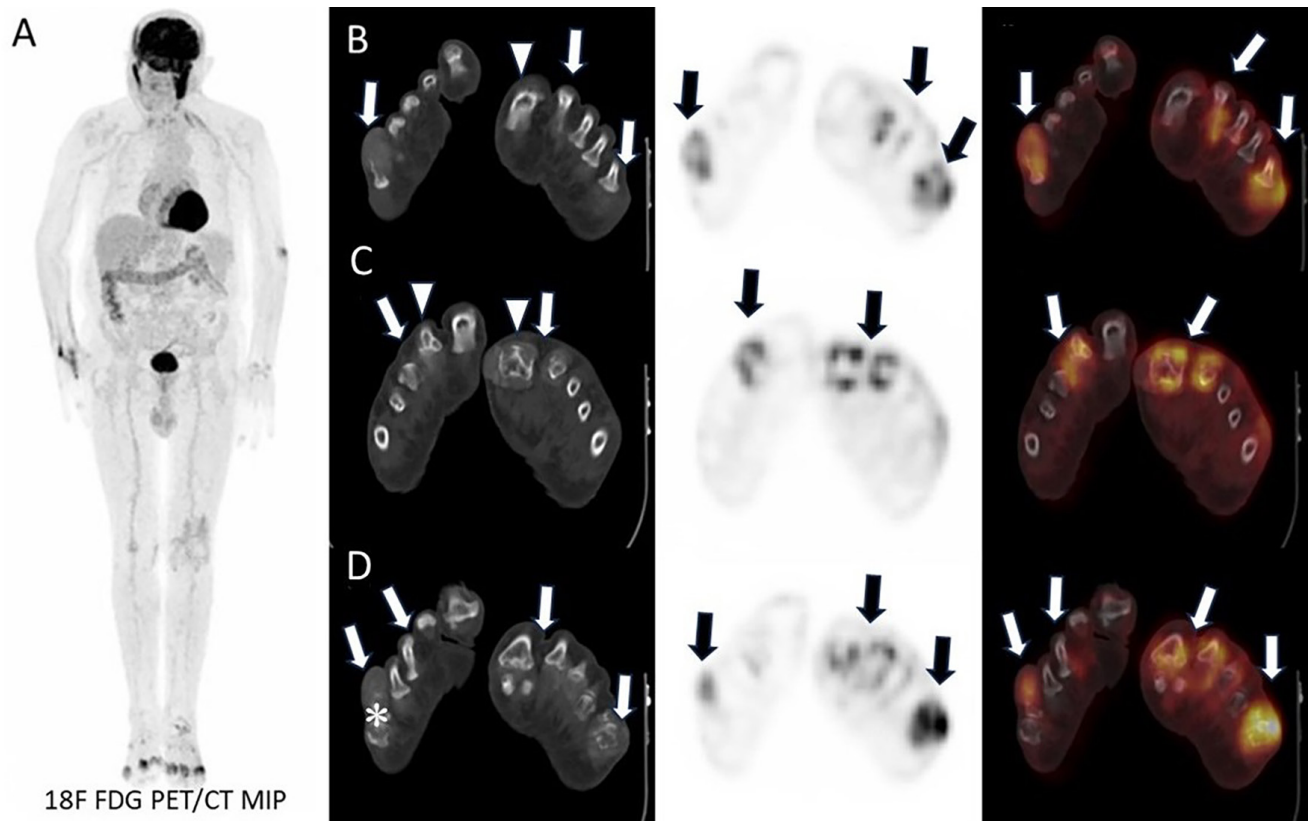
An 84-year-old man, with a known history of hypertension, asthma, and coronary artery disease, presented to the orthopedics clinic with complaints of acute swelling and pain in the right fifth toe. The patient had not experienced similar complaints previously. Magnetic resonance imaging revealed T2 hyperintense nodular images on the articular surfaces of the 1st and 2nd metatarsophalangeal joints of the right foot. A hyperintense mass was observed on imaging distal to the 2nd metatarsal, extending to the phalanx, disrupting the cortex, and spreading into the soft tissue. Additionally, a mass was detected in the distal phalanx of the 5th toe which destroys the bone cortex and extends into the soft tissue. To rule out malignancy, ^{18}F -fluorodeoxyglucose positron emission tomography/computed tomography (^{18}F -FDG PET/CT) was performed (A). Significant increased ^{18}F -FDG uptake was detected in bilateral intertarsal, tarsometatarsal, metatarsophalangeal, and interphalangeal joints which was more pronounced on the left side (line B, C, and D: arrows). CT images revealed destruction of the cortices of the bones adjacent to the metatarsophalangeal joint surfaces (line B, C: arrowhead), and soft tissues around the joints (line D: asterix) While active symmetric bilateral arthritis was primarily considered, no findings suggestive of malignancy were found in the other parts of the body.
